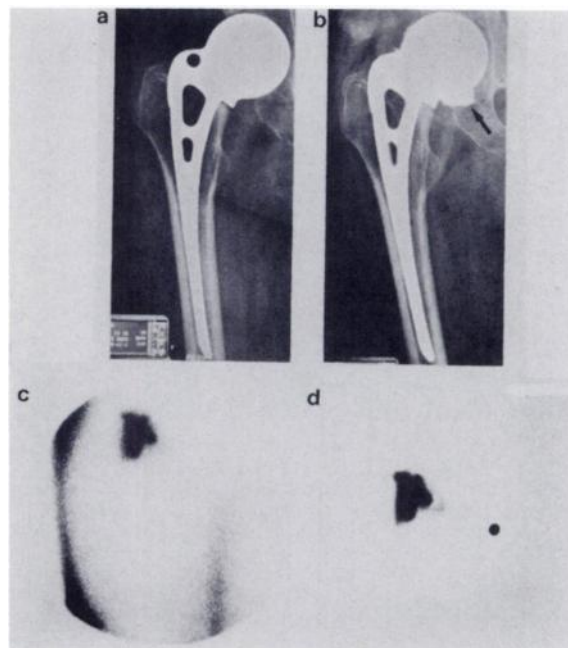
Negative XA and RA (a) Plain film. (b) Radiographic arthrogram; arrow points to contrast limited to region of joint space. (c) Co-57 transmission image. (d) Tc-99m arthrogram also shows activity in region of joint space. Black dot in d is Tc-99m marker on symphysis pubis.
